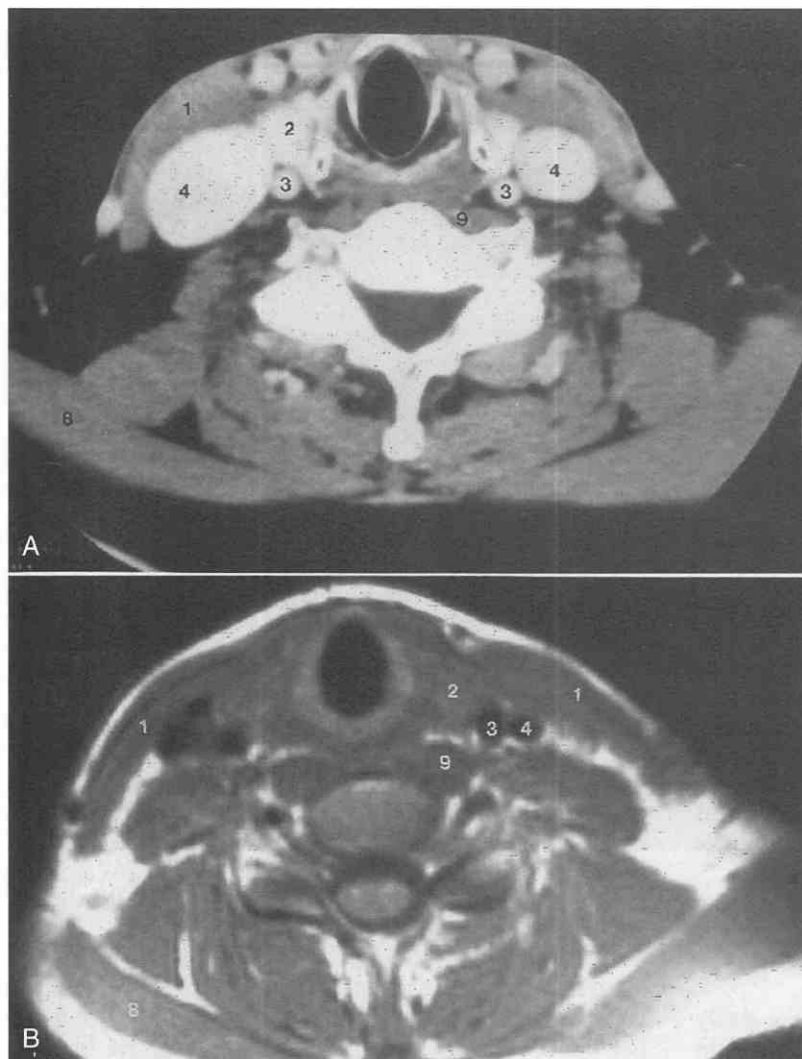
Normal axial anatomy at the level of the cricoid cartilage and inferior cornua of the thyroid cartilage. *A*, CT scan. The asymmetry in the diameters of the internal jugular veins is a normal variant. *B*, T1-weighted MR image. 1, Sternocleidomastoid muscle; 2, thyroid gland; 3, internal carotid artery; 4, internal jugular vein; 8, trapezius muscle; 9, longus colli muscle.
